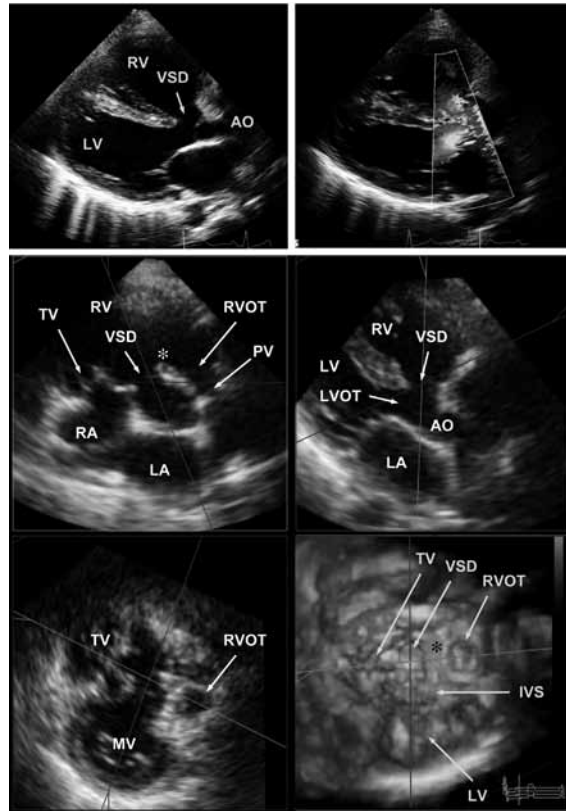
Comparison of 2D and RT3DE representations of a Fallot's tetralogy in a 25-year-old woman presenting with the characteristic combination of overriding aorta, perimembranous (subaortic) ventricular septal defect (VSD), pulmonary valve (PV) stenosis, and right ventricular hypertrophy. The 2D color Doppler image clearly shows direct right ventricular outflow (blue) towards the overriding aorta (AO) (top right). The 3D en face view from the apex to base (bottom right) shows the location of the VSD – connecting the RV to the aorta – located on a (green) line between the tricuspid valve (TV) and right ventricular outflow tract. The right ventricular outflow tract (RVOT) is quite wide for a tetralogy of Fallot. The green plane (middle left) also depicts the relation between the TV, VSD, and RVOT with the typical ventricular infundibulum deviated anteriorly (*) between the LVOT and RVOT, the hallmark of Fallot's tetralogy. LV left ventricle, RV right ventricle, RA right atrium, LA left atrium, MV mitral valve, LVOT left ventricular outflow tract, IVS interventricular septum.
